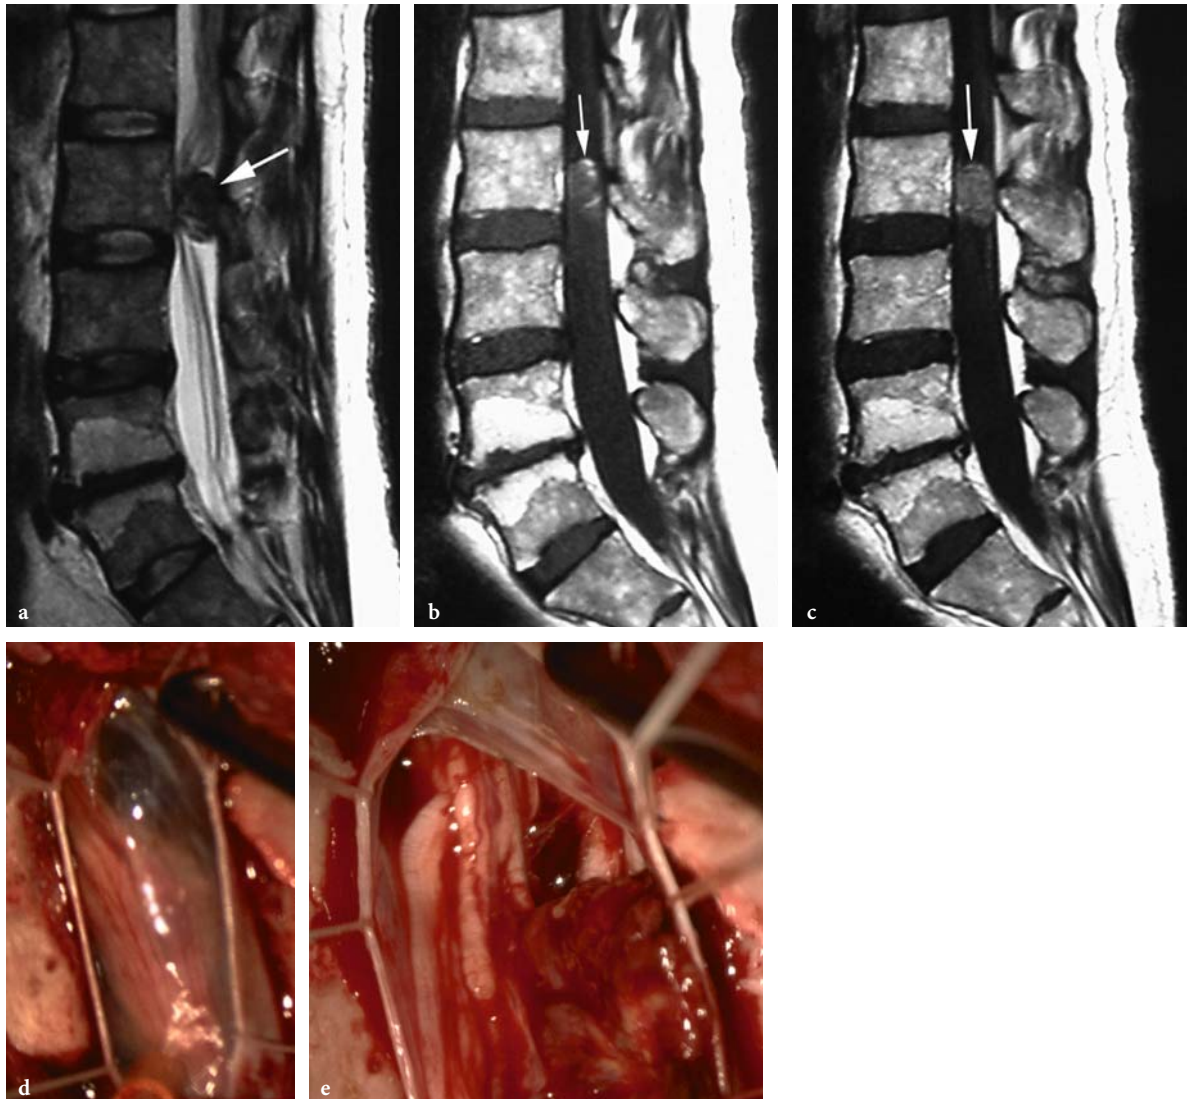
Cauda equina intradural metastasis from renal cell carcinoma in a 61-year-old man with a 10-month history of worsening lower back pain that radiated to both legs. a Sagittal spin-echo T2-weighted MR image shows intradural hypointense lesion (*arrow*) involving the cauda equina at the level of L2. b Sagittal unenhanced T1-weighted MR image shows small heterogeneous hyperintense areas within the ill-defined tumoral lesion (*arrow*). c Sagittal contrast-enhanced T1-weighted MR image shows a slight but homogeneous enhancement of the lesion (*arrow*) which appears more conspicuous. Intraoperative photographs d before and e after dural opening clearly show brown necrotic encapsulated tumor, which displays several nerves that run directly to the tumor. Macroscopically, the tumor contains old hemorrhagic and necrotic tissue corresponding to the imaging findings. (Image courtesy of M. DOITA)
